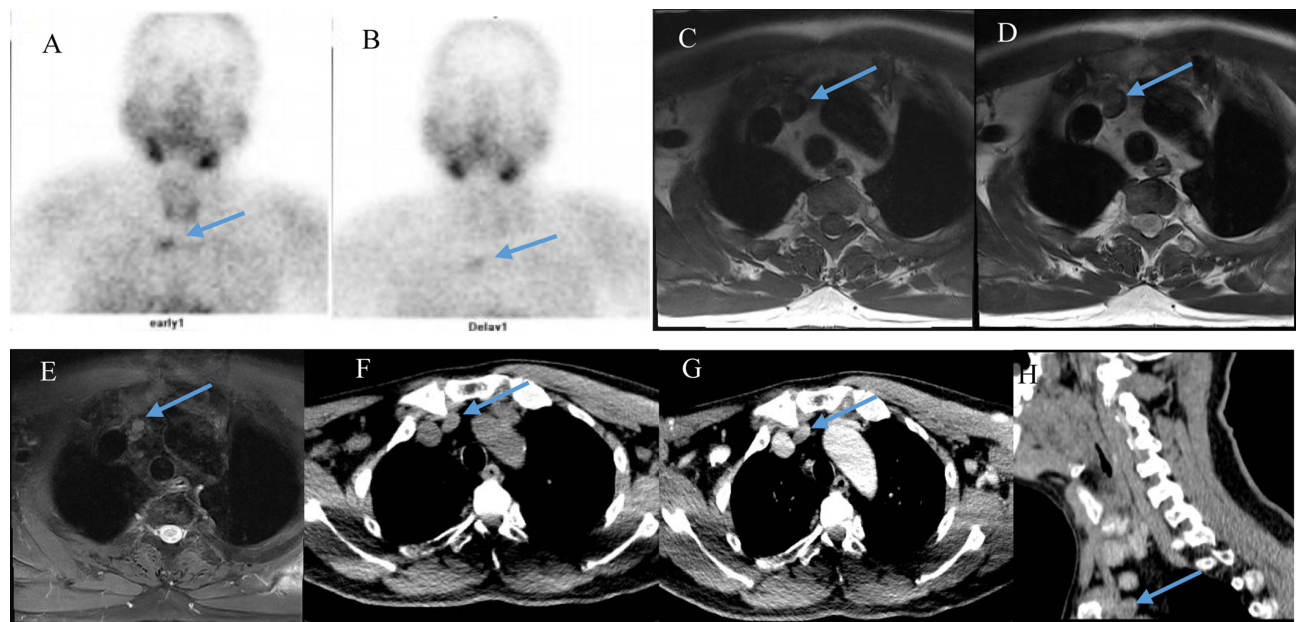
Patient I: Dual-phase ^{99m}Tc -sestaMIBI planar images at early 10 minutes and delayed 2 hours (A and B) reveal tracer high uptake. MRI images (C–E) and CT transaxial, and sagittal images (F–H) shows a lesion in the right side of superior mediastinum (arrow).
